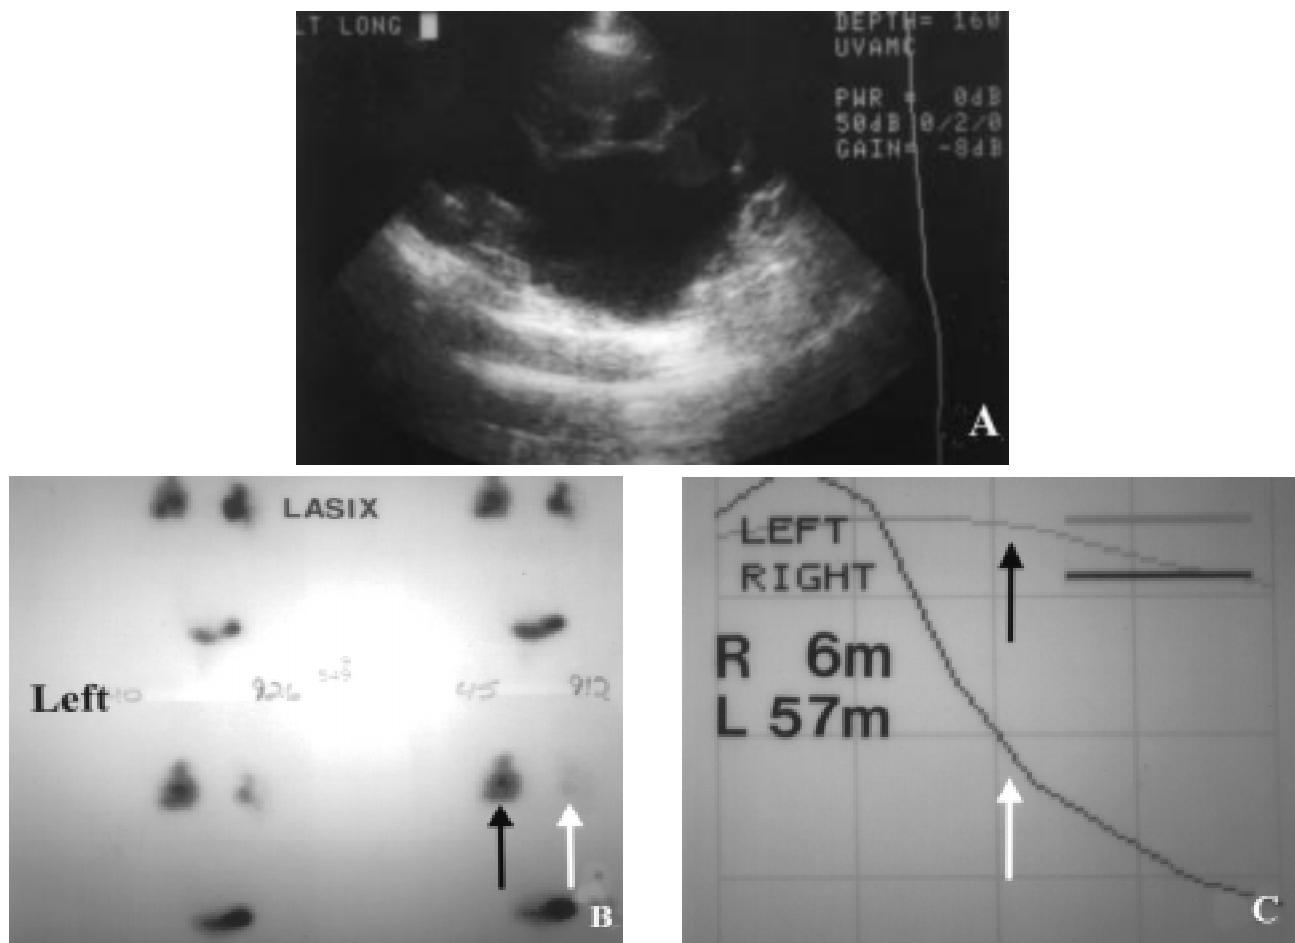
A)- Renal ultrasound shows dilated pelvis and calyces in a patient with congenital left UPJ obstruction; B)- Lasix renal scan shows delayed washout of left kidney (black arrow) compared to the normal right kidney (white arrow); C)- Washout curves confirm delayed emptying of the left system (black arrow) with an elevated $T_{1/2}$ of 57 minutes compared to the normal right system (white arrow) with a normal $T_{1/2}$ of 6 minutes.
